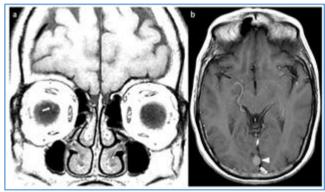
MRI (See the arrow pointing at the lesion)
